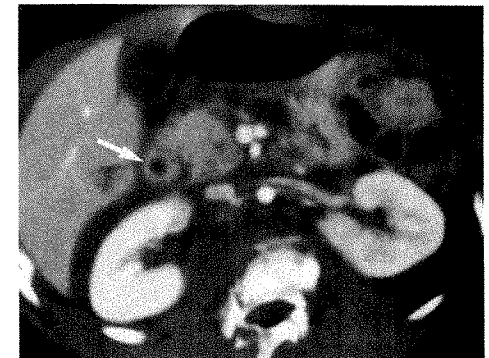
CT scan shows thickening of second part of duodenum (arrow) and a retroperitoneal hematoma in a 7-year-old girl who has been paraplegic since she was involved in a car accident while wearing a lap belt. L2 vertebra is shattered. No solid organ injuries were identified. At surgery, a transection of the second part of duodenum was found.
